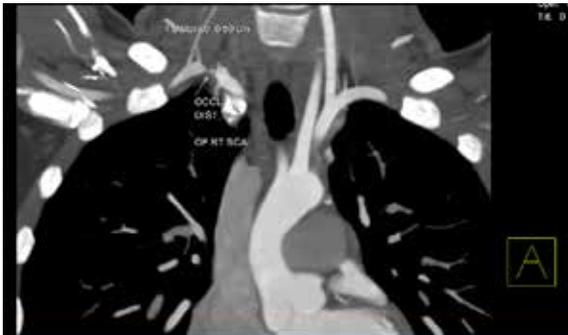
CT ANGIO DEPICTING OCCLUSION OF RT SCA.
